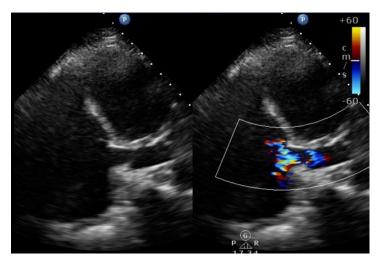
Transthoracal echocardiography showed a dilatation of coronary sinus draining to RA.
